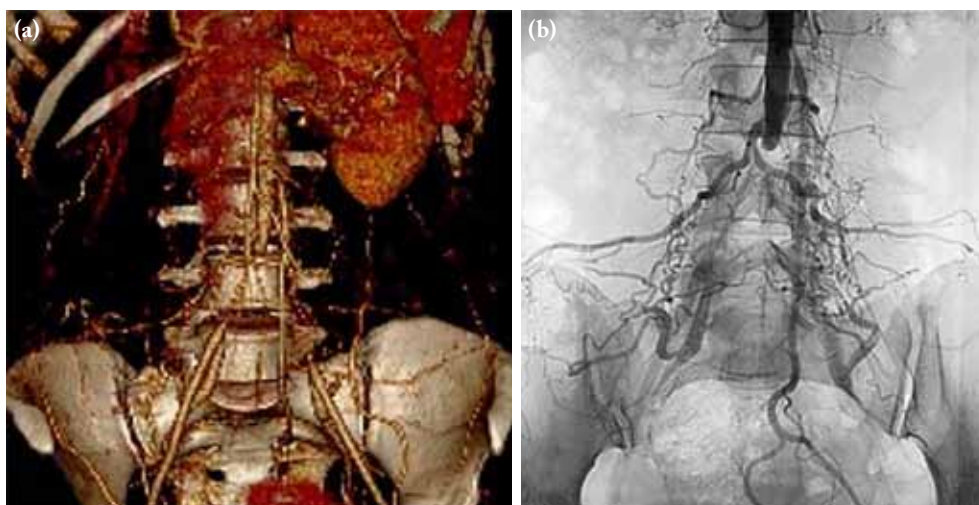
Computed tomography angiography (a) and pre-interventional angiography (b) showing chronic aortoiliac occlusion with reperfusion of the external iliac arteries via collaterals.
